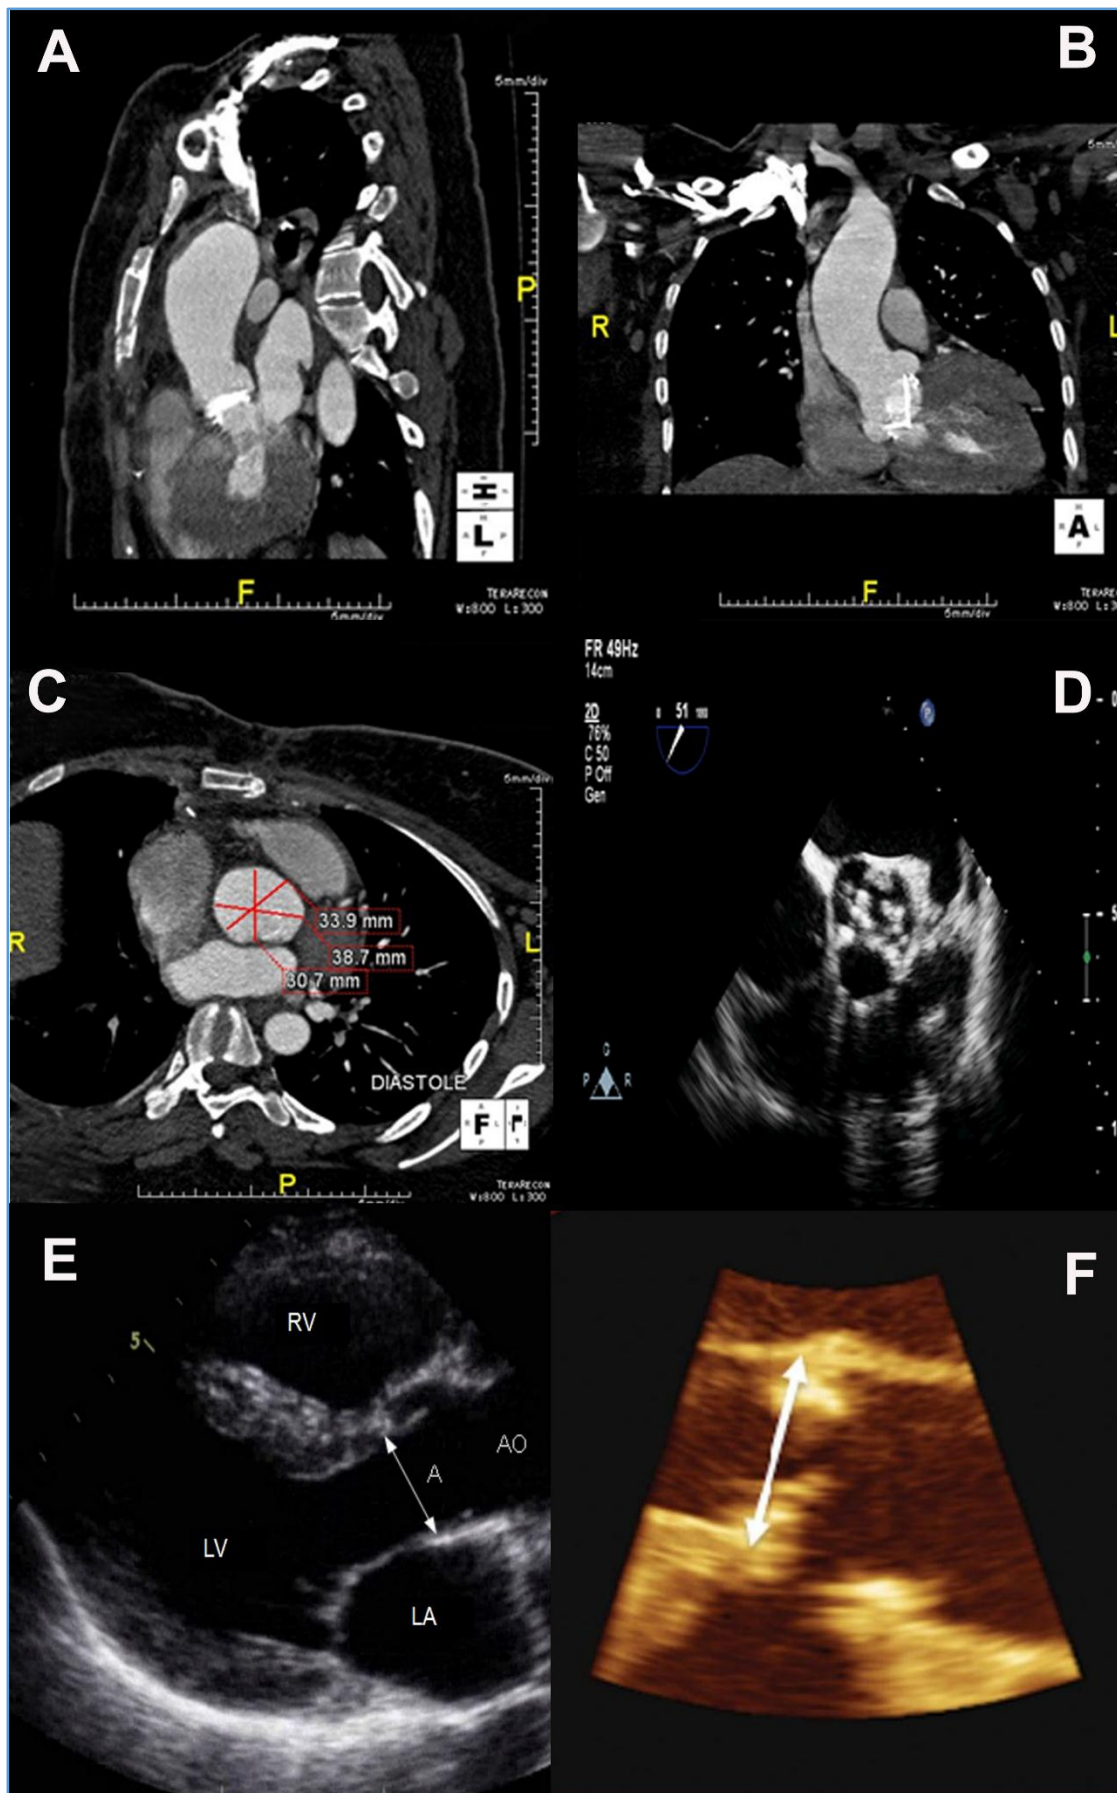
CT and Echocardiographic Images showing Measurement of Aortic Annulus: a) Sagittal View - CT Angiography b) Coronal View - CT Angiography c) CAAD Measurement by Planimetry Method d) 2-D Transesophageal Measurement e) 2-Dimensional Transthoracic Echocardiography f) 3-Dimensional Transesophageal Echocardiography
